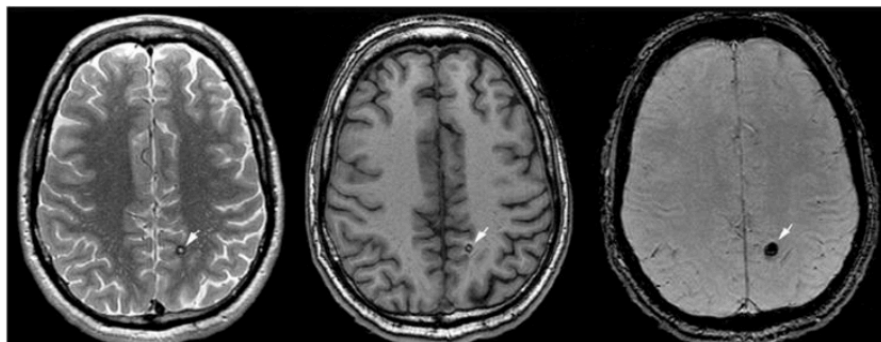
Axial MRIs (proton density, T1, T2-weighted) showing cavernous malformation as CMB mimic (arrows).
